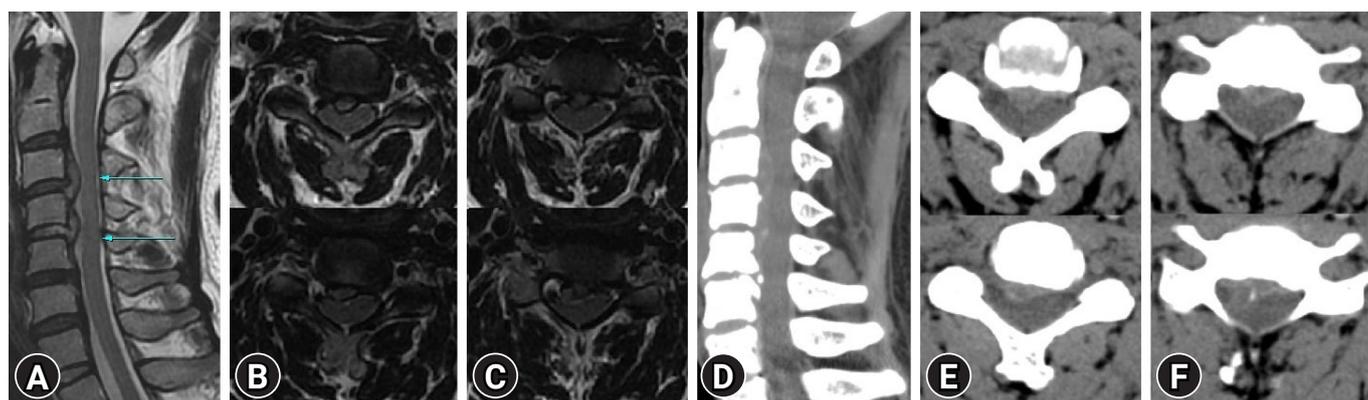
Preoperative images of the up migrated cervical disc herniation at C3-4, C4-5 level on MRI and CT. (A) A mid-sagittal image on T2 weighted MRI. (B) Axial images at C3-4 level on T2 weighted MRI. (C) Axial images at C4-5 level on T2 weighted MRI. (D) Mid-sagittal images on CT. (E) Axial images at C3-4 level on CT. (F) Axial images at C4-5 level on CT.
